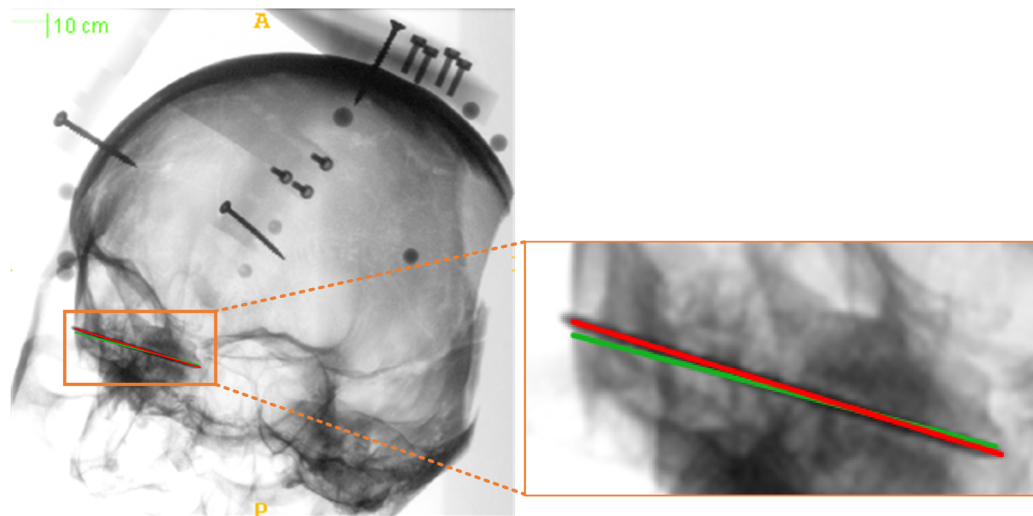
Visualization of the current drill bit position and the planned drilling path on an X-ray image.
